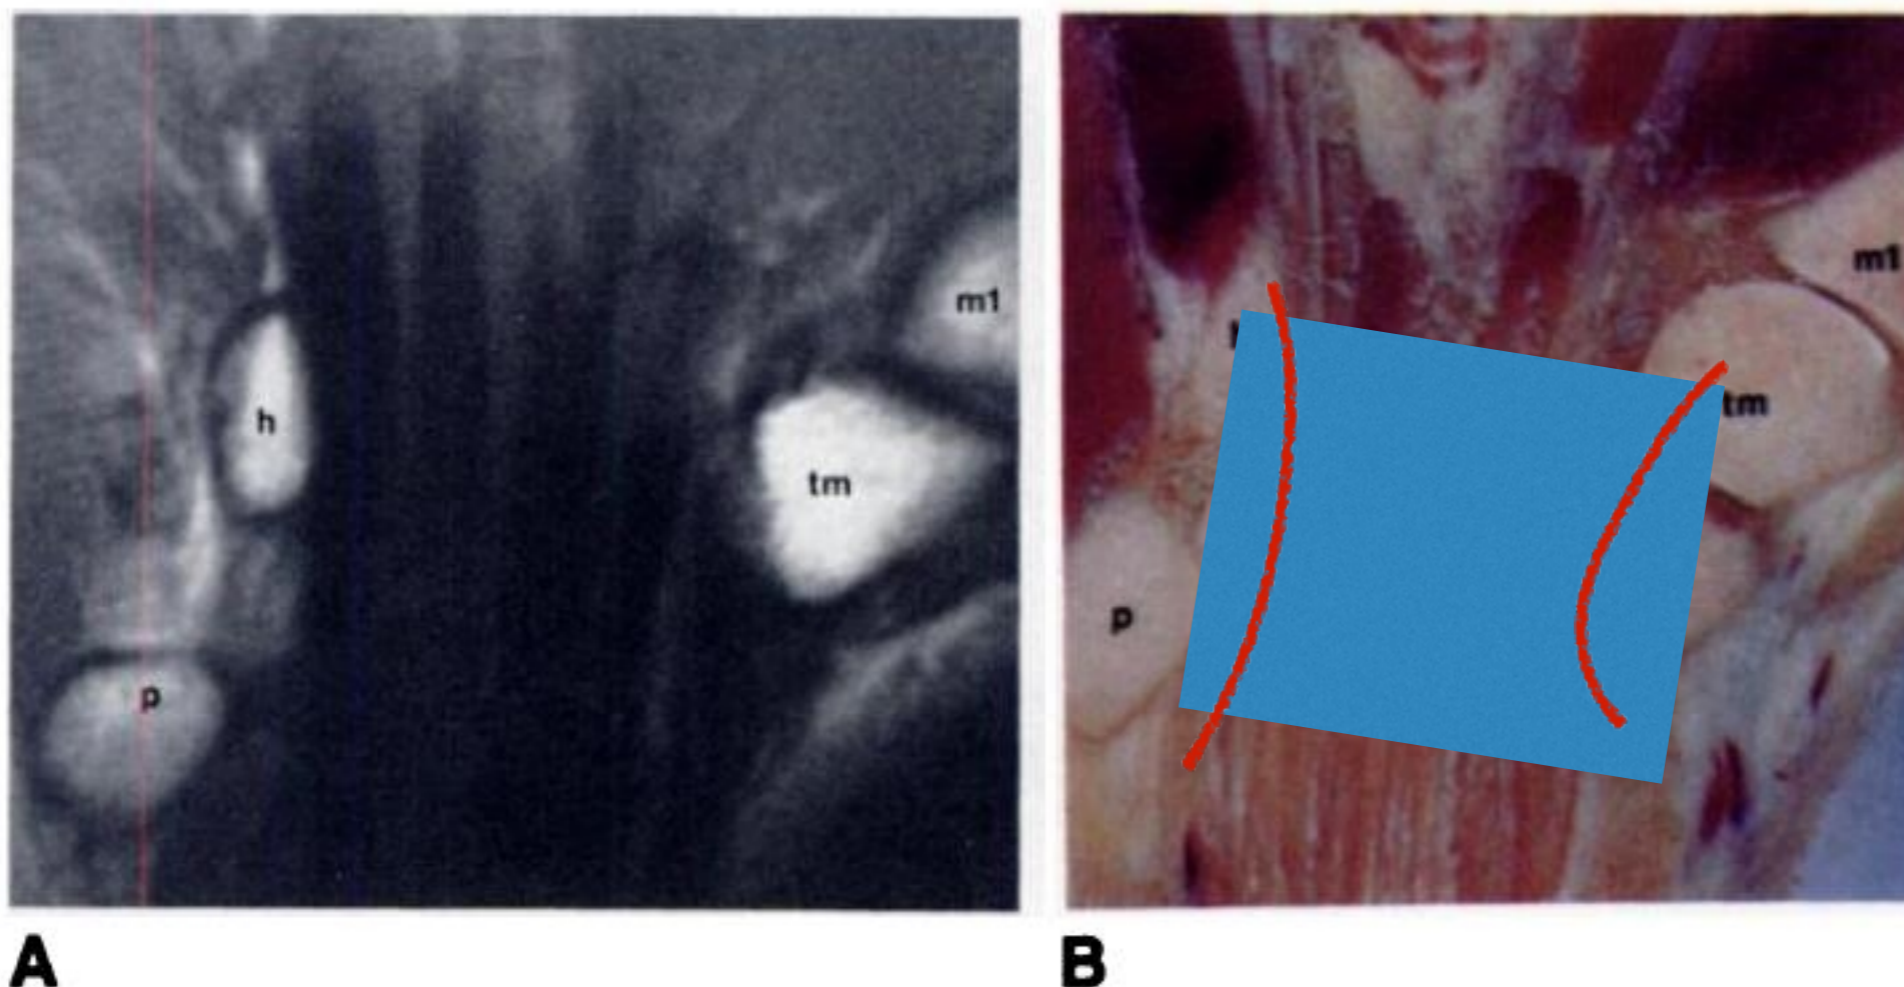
Coronal MR image (TR 600, TE 25) (A) and anatomic section (B) through hook of hamate, pisiform, and tubercle of trapezium. (See key for abbreviations.)
